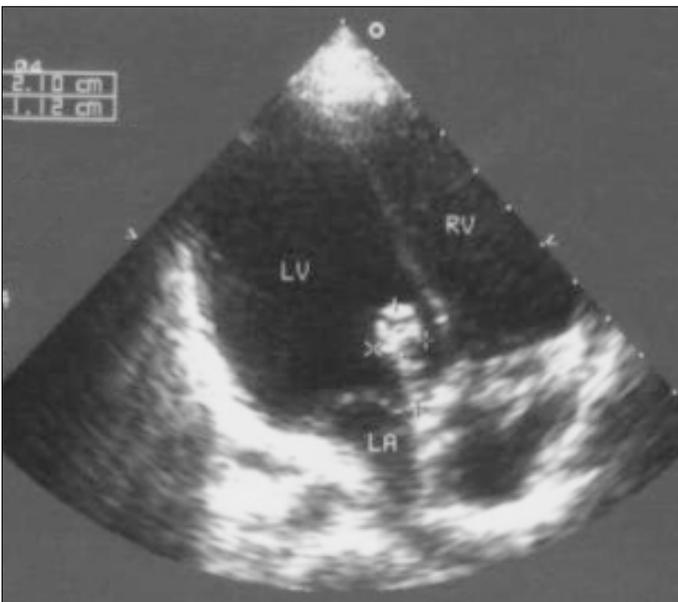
Transthoracic echocardiography three years after the operation. A hyperechogenic recurrent mass is seen in the previous localization
